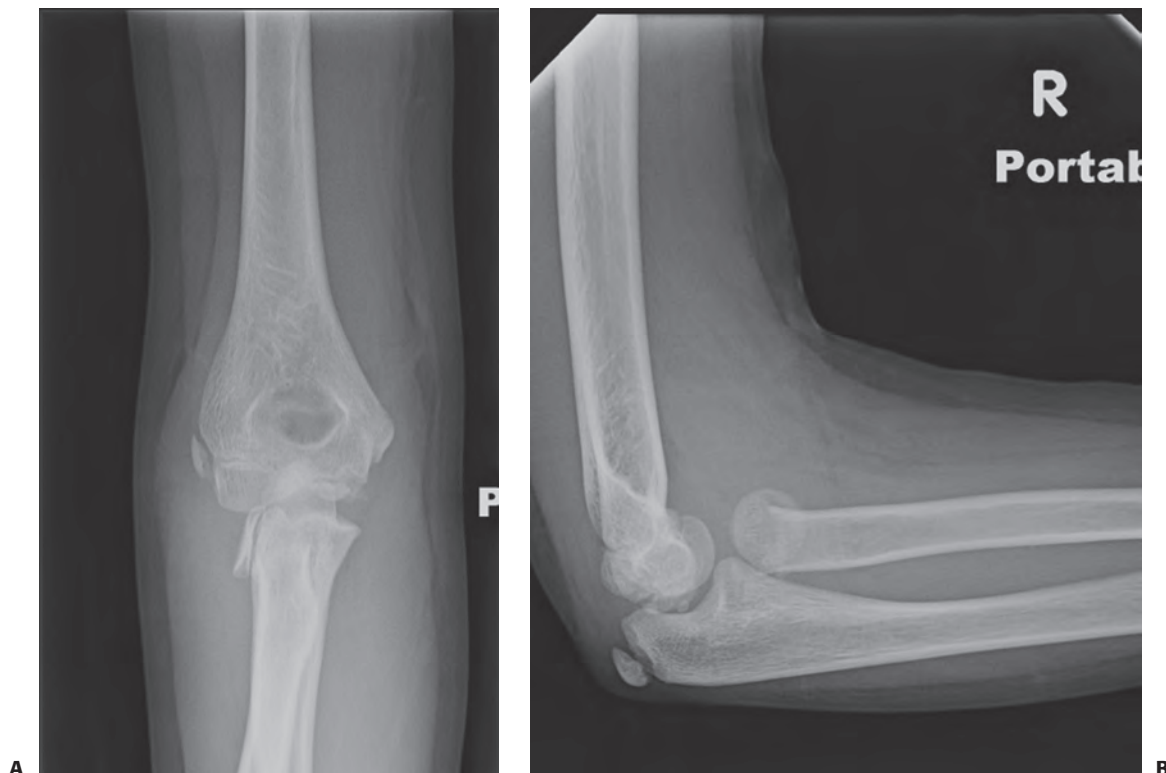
Instrument-assisted closed reduction of the proximal radius. A: AP radiograph of an angulated radial neck fracture in a 10-year-old female. B: Lateral radiograph of the same patient.
